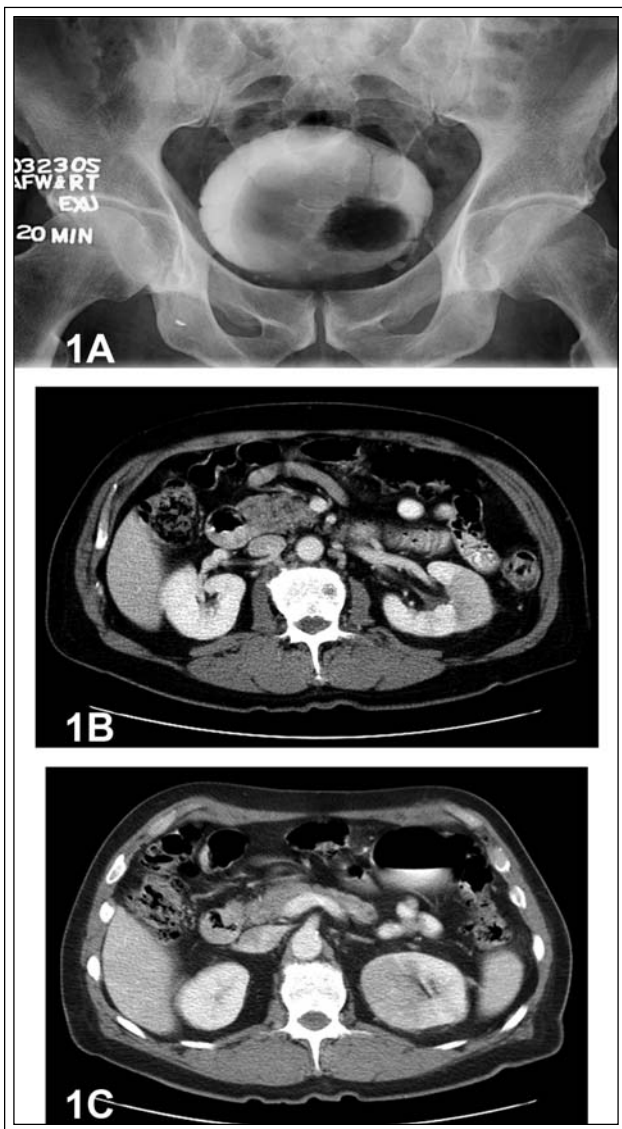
Excretory urogram of bladder lesion and CT scan of renal mass. a) Excretory urogram demonstrating the filling defect in the left wall of the bladder consistent with bladder tumor. b) CT scan demonstrating left sided heterogenous renal mass. c) Left renal mass demonstrating contrast enhancement.
